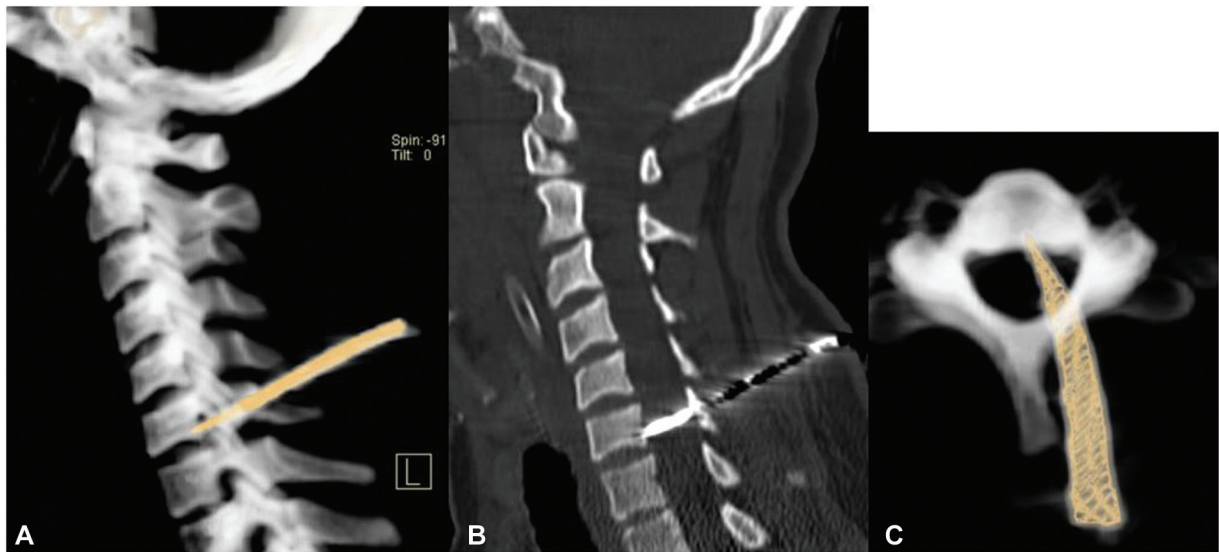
Computed tomography cervical spine: (A, B) Sagittal images showing the path of impaled knife passing through C5 lamina, across the spinal canal onto C6 vertebral body. (C) Axial image showing knife resting over C5 vertebral body passing through the canal.
